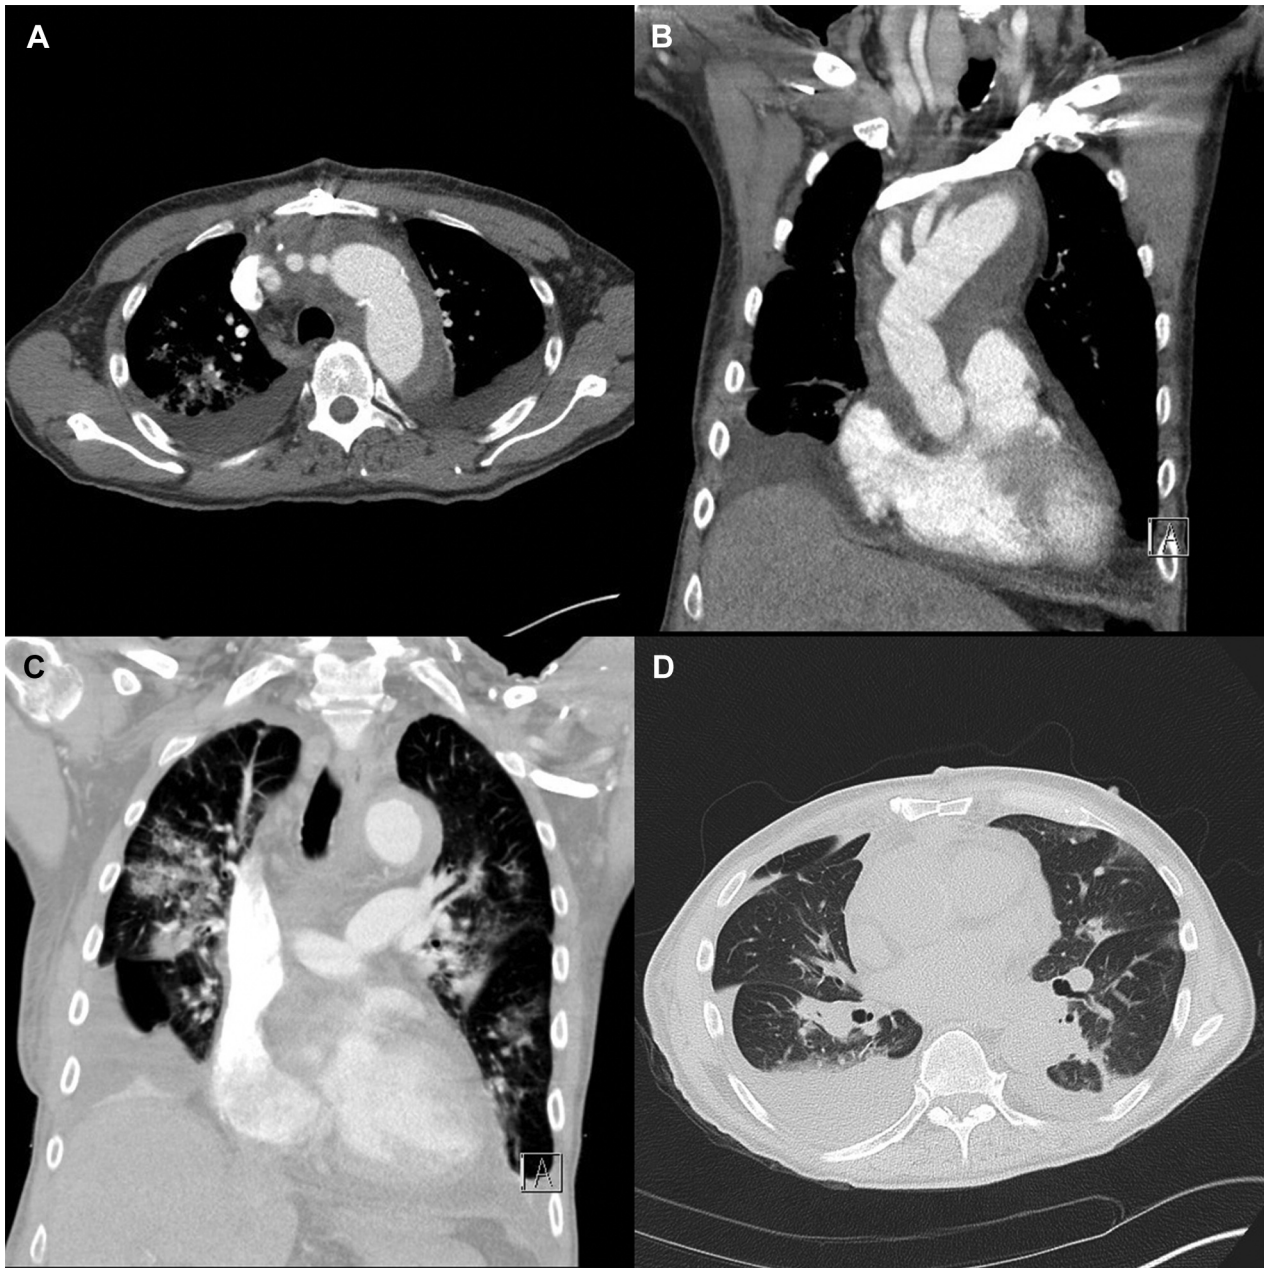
Computed tomography on postoperative day 9. (A) Transverse plane: prosthesis with branches, bilateral pleural fluid. (B) Coronal plane: ascending and arch reconstruction with arch branching. (C) Coronal plane: bilateral pleural effusion and infiltration. (D) Transverse plane: pleural effusion and perihilar infiltration.
